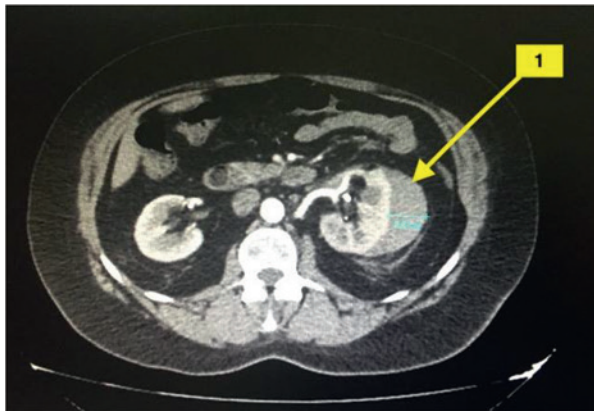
Contrast-enhanced computed tomography of the urinary system, 1 – subcapsular hematoma of the left kidney after flexible URS
